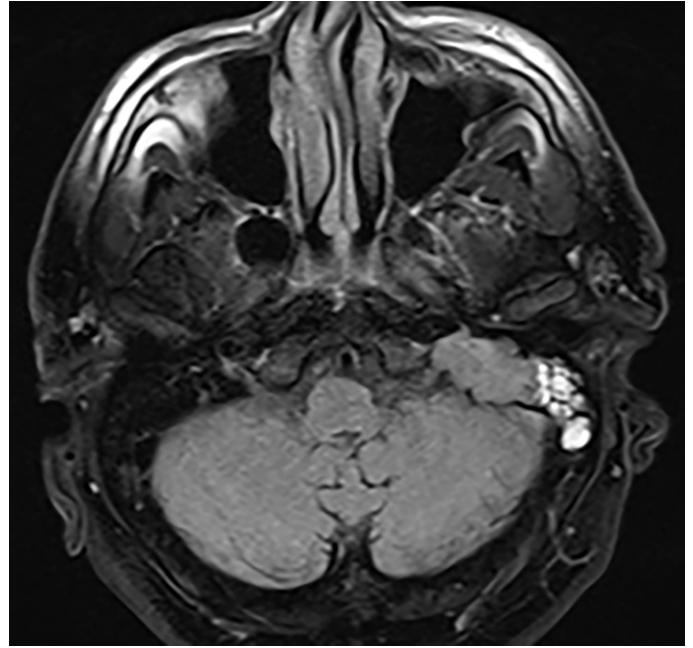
Axial FLAIR MR image reveals the tumor mass to be a hypointense signal intensity compared to the high signal obstructed mastoid secretions.
